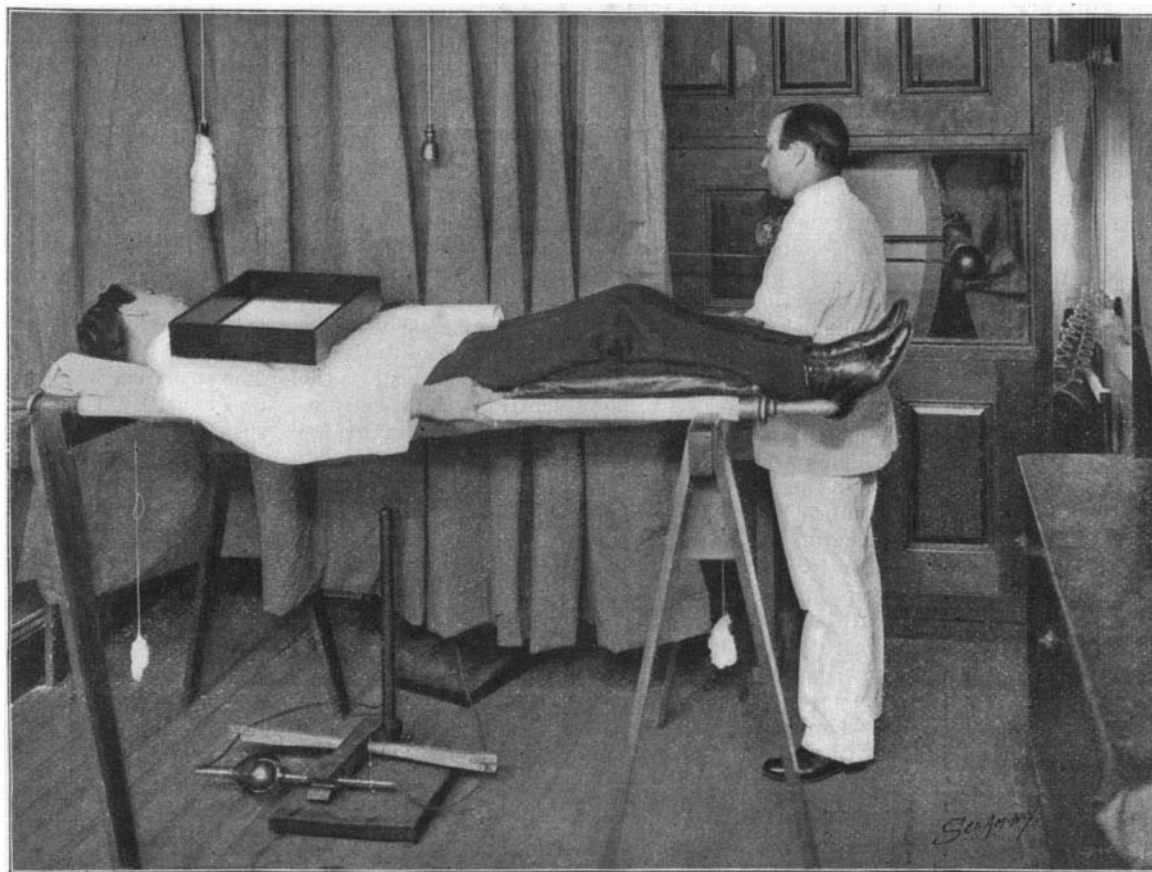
METHOD OF MAKING X-RAY EXAMINATION.
